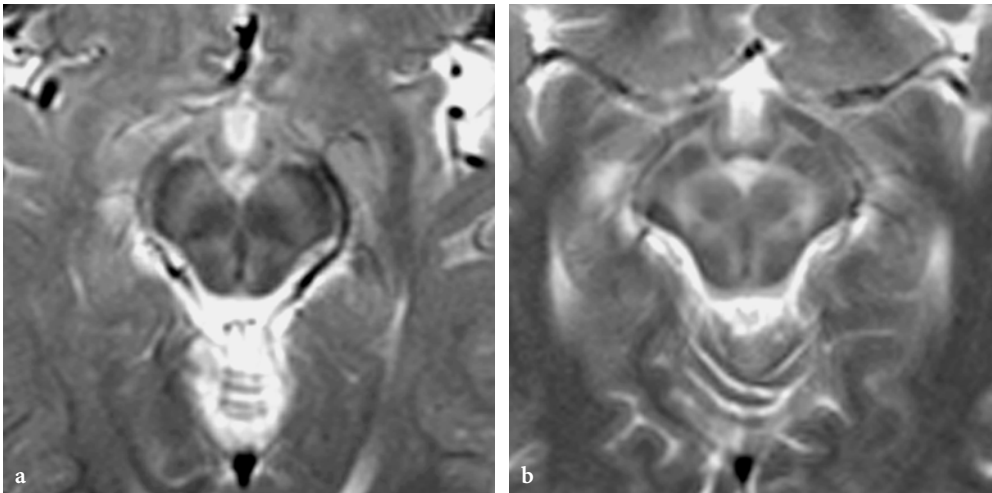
The “giant panda face” appearance of the upper mesencephalon on T2-weighted fast spin-echo images in metabolic diseases. a 1-year-old male patient with glutaric aciduria type 1. The cerebral peduncles, the red nuclei and the tectum are normal (hypointense), whereas the substantia nigra and the periaqueductal white matter exhibit increased signal. b 16-year-old male patient with Wilson disease. Similar findings as on Figure 13.11a
